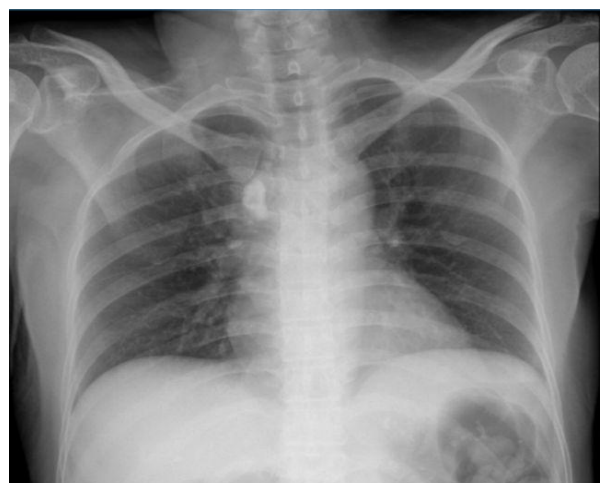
Chest x-ray showed suspicion of calcification in the lymph nodes.
